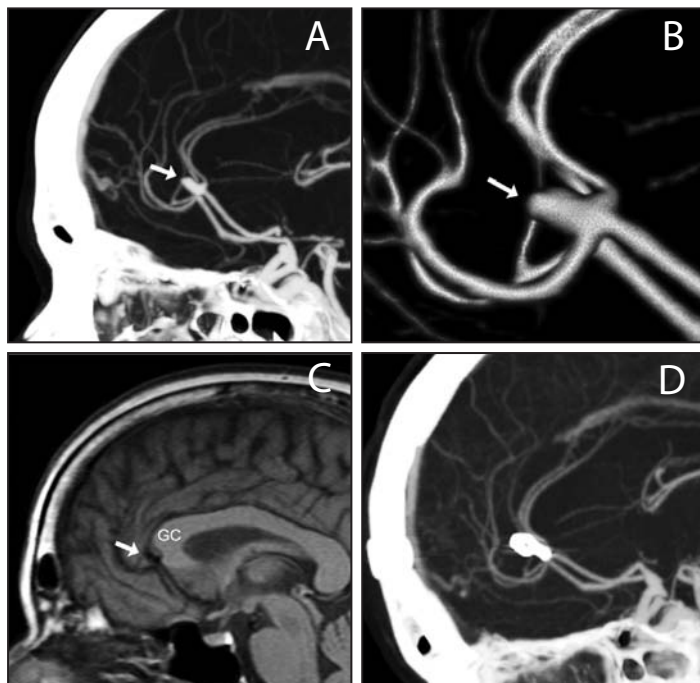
Unruptured inferior A3A (arrow) as seen on (A) preoperative 2D CTA, (B) preoperative 3D CTA, (C) preoperative MRI, and (D) postoperative CTA (see DACA — video 6).
